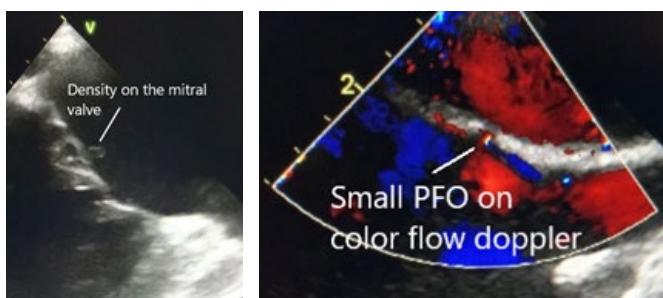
On the left: Small density suggestive of a vegetation on the mitral valve. On the right: Small PFO seen on color flow doppler.
